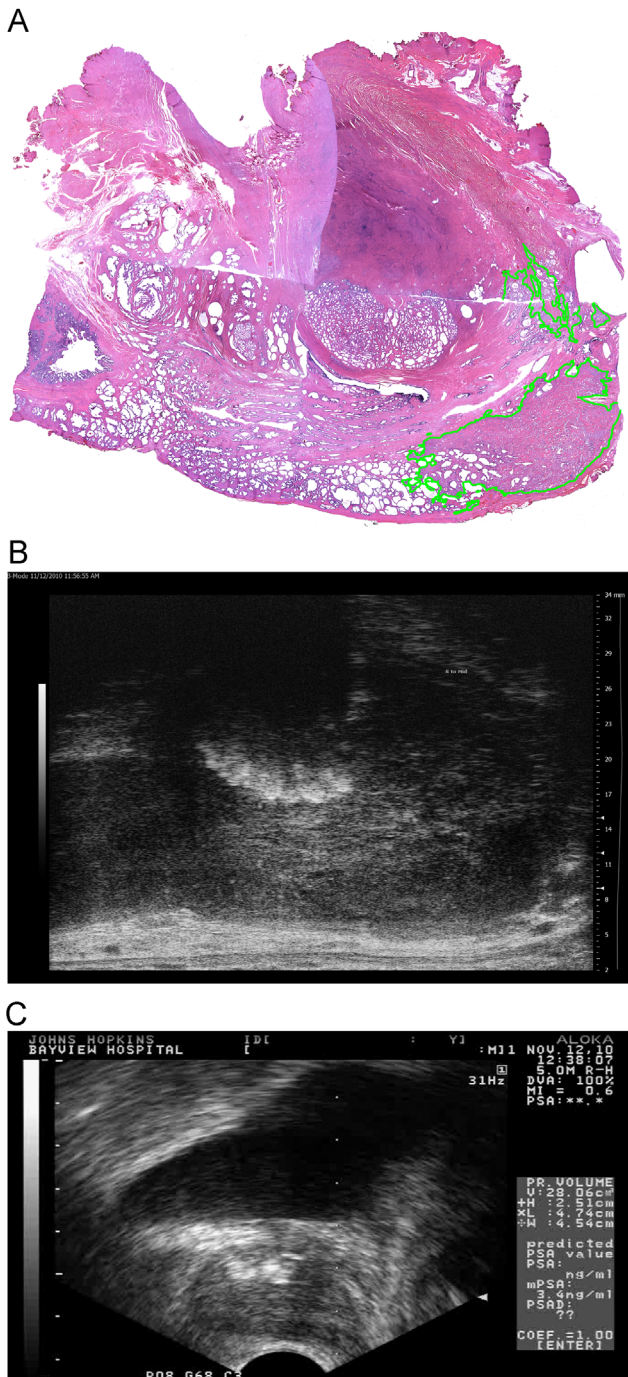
(A) Reconstructed sagittal prostate section with Gleason 3 + 4 = 7 tumor at left apex outlined in green ink. This corresponds to a hypoechoic lesion most accurately identified on high-resolution transrectal ultrasound (B). The lesion is less clearly defined on low-resolution transrectal ultrasound and could be missed (C). (Color version of figure is available online.)
